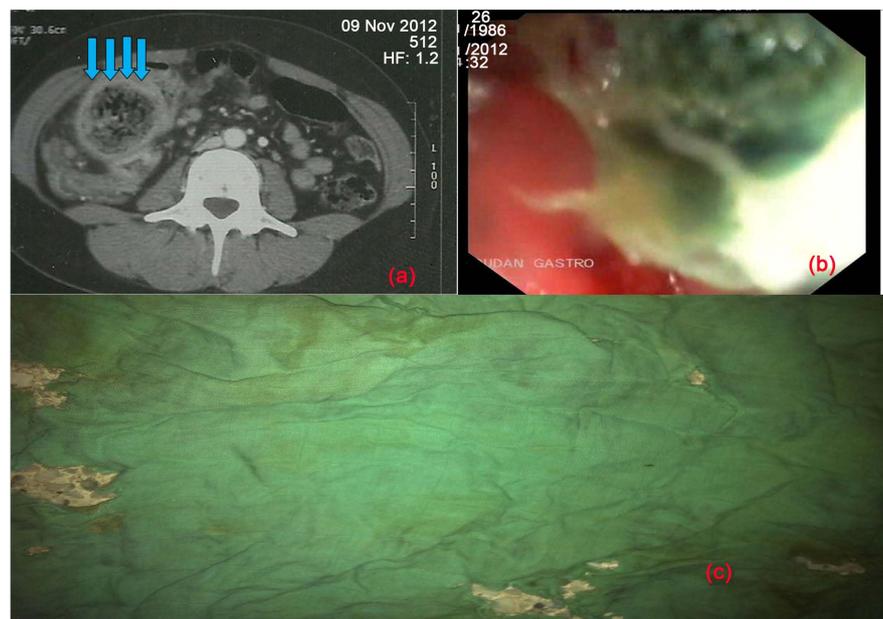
(a) CT scan showing a right iliac fossa mass; (b) Endoscopic image of textiloma; (c) Textiloma after rectal expulsion.
